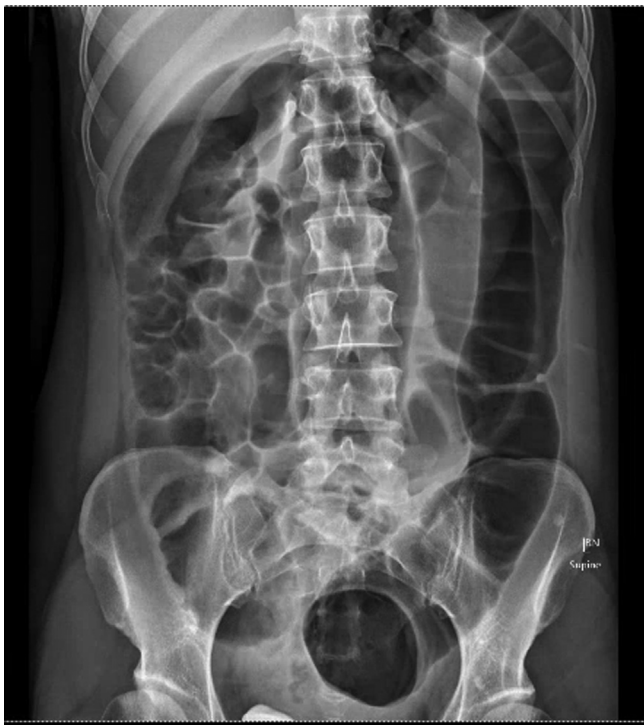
Abdominal x-ray showing very dilated colon down to the rectosigmoid junction.
